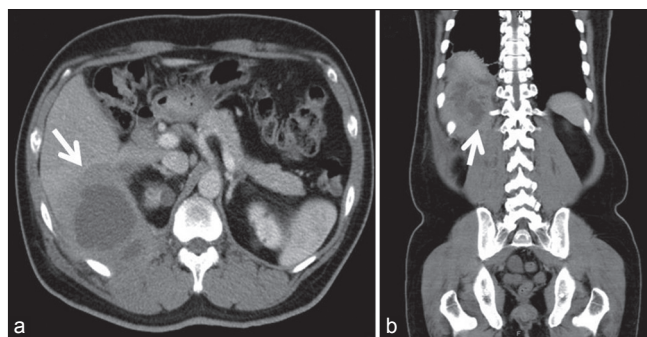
(a) Axial view of abdomen computed tomography (CT): A large cystic lesion (>10 cm) with irregular wall thickening is noted over the inferior segment of the right lobe of the liver. (b) Coronal view of abdomen CT: The lesion involves the right quadratus lumborum muscle, the right erector spinae muscle, and the inferior segment of the right lobe of the liver
